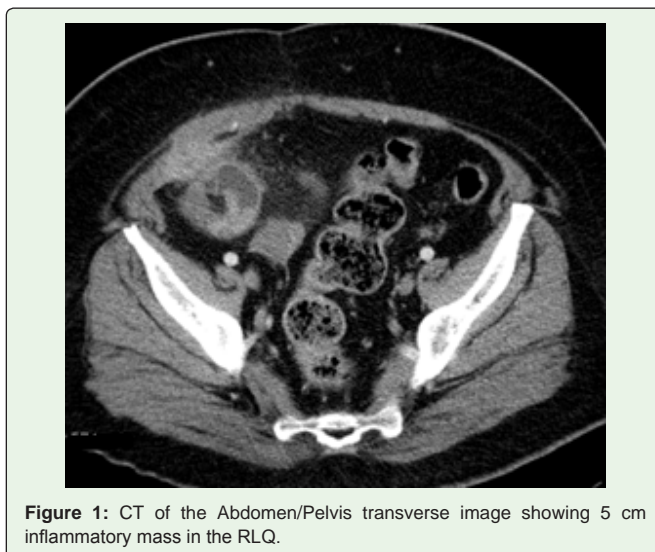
CT of the Abdomen/Pelvis transverse image showing 5 cm inflammatory mass in the RLQ.
